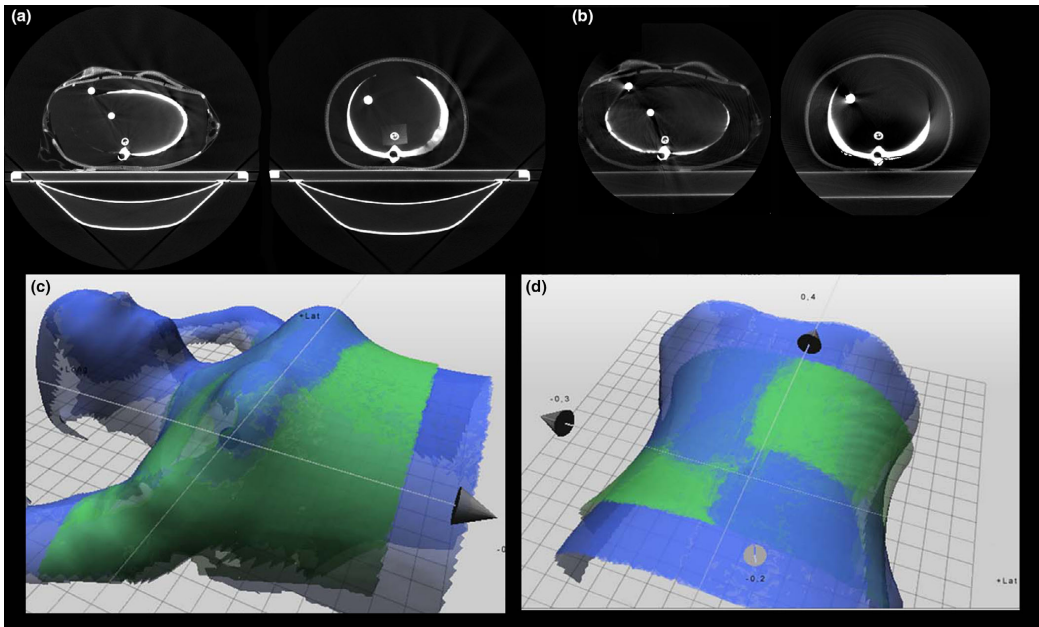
Some selected slices of computed tomography (CT) (a) and cone-beam CT (CBCT) (b) acquisitions of Mary. In (c) and (d), two examples of Catalyst<sup>TM</sup> acquisitions showing the reference surface images in green and the live surface images in blue. Torsion of Mary around the y-axis is shown in (d), where the blue and the green surfaces no longer overlap, and the live surface is either above or below the reference surface resulting in a chess pattern. [Color figure can be viewed at [wileyonlinelibrary.com](http://wileyonlinelibrary.com)]
